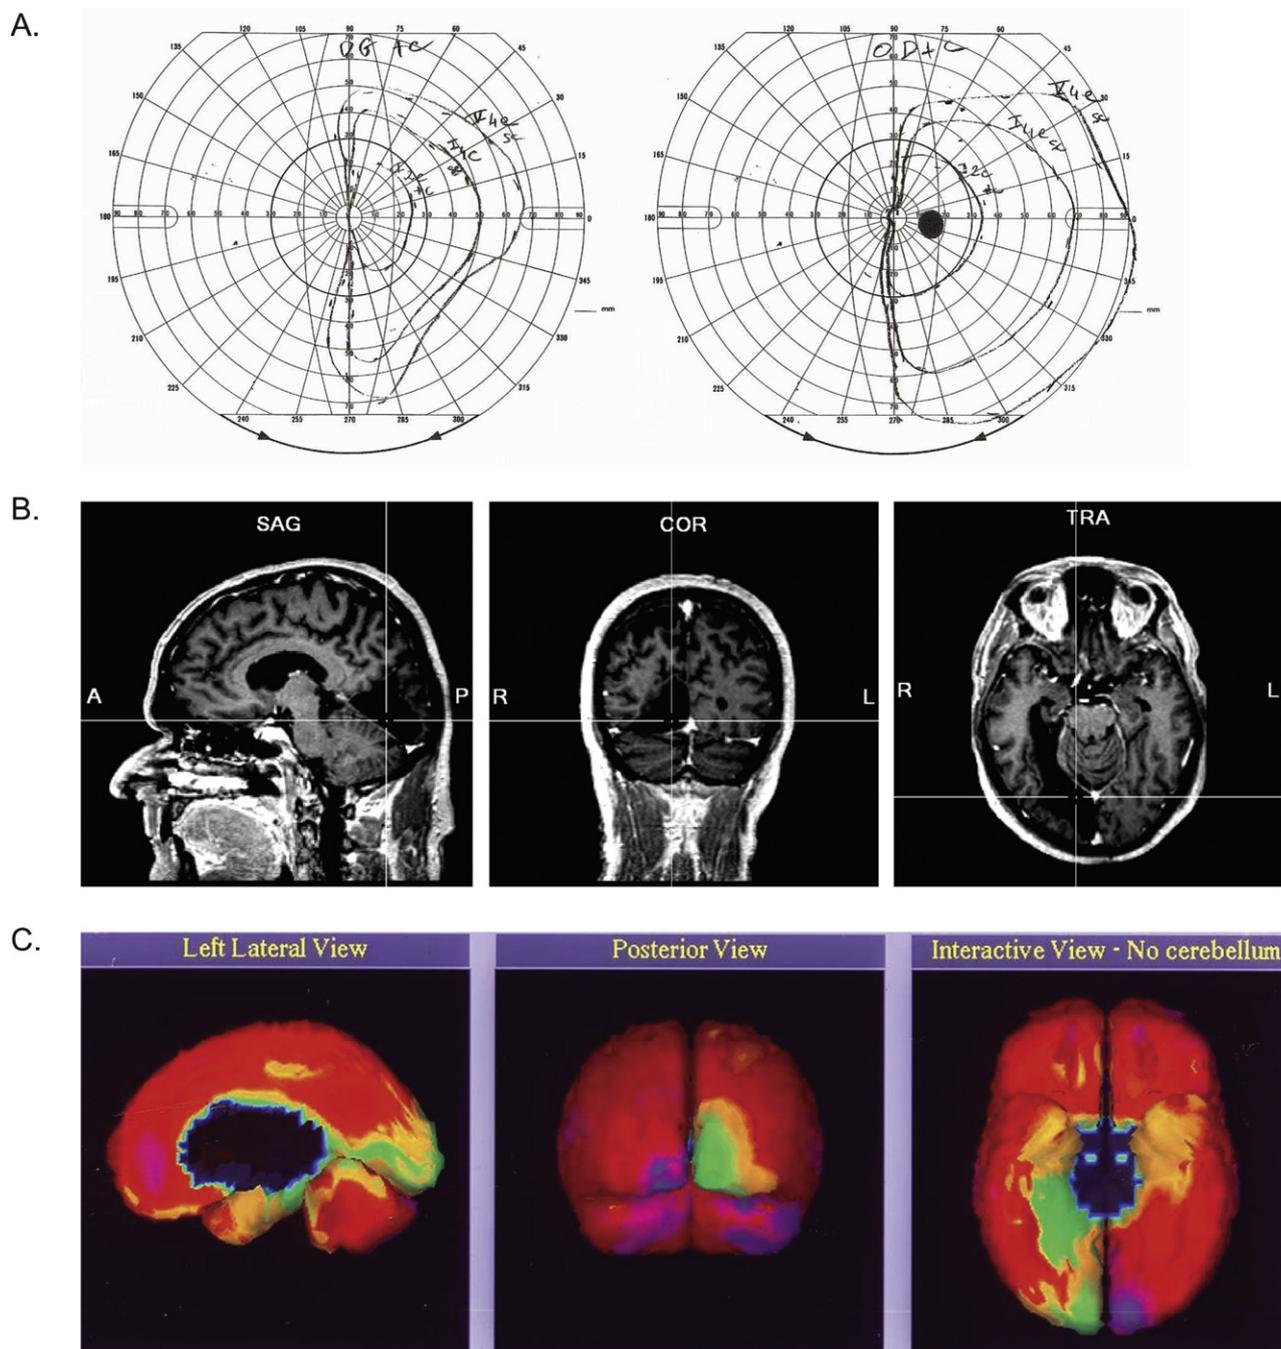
(A) GG's ophthalmologic assessment showing a left lateral homonymous hemianopsia. (B) GG's structural MRI showing clear damaged brain tissue in the occipital lobe, the fusiform gyrus, and the parahippocampal gyrus, unilaterally in the right hemisphere. (C) 3D Talairach cortical perfusion report showing hypoperfusion restricted to the internal parts of the right occipito-temporal cortex.
